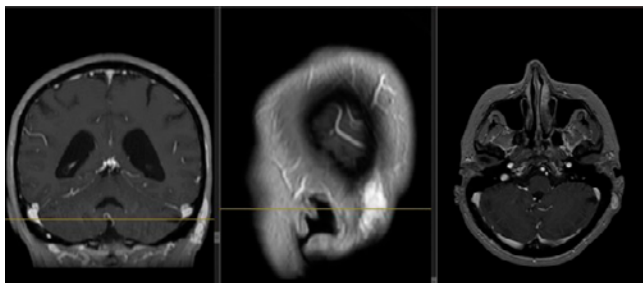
Contrast-Enhanced Head MRI Scan – left retroauricular pseudotumoral formation
